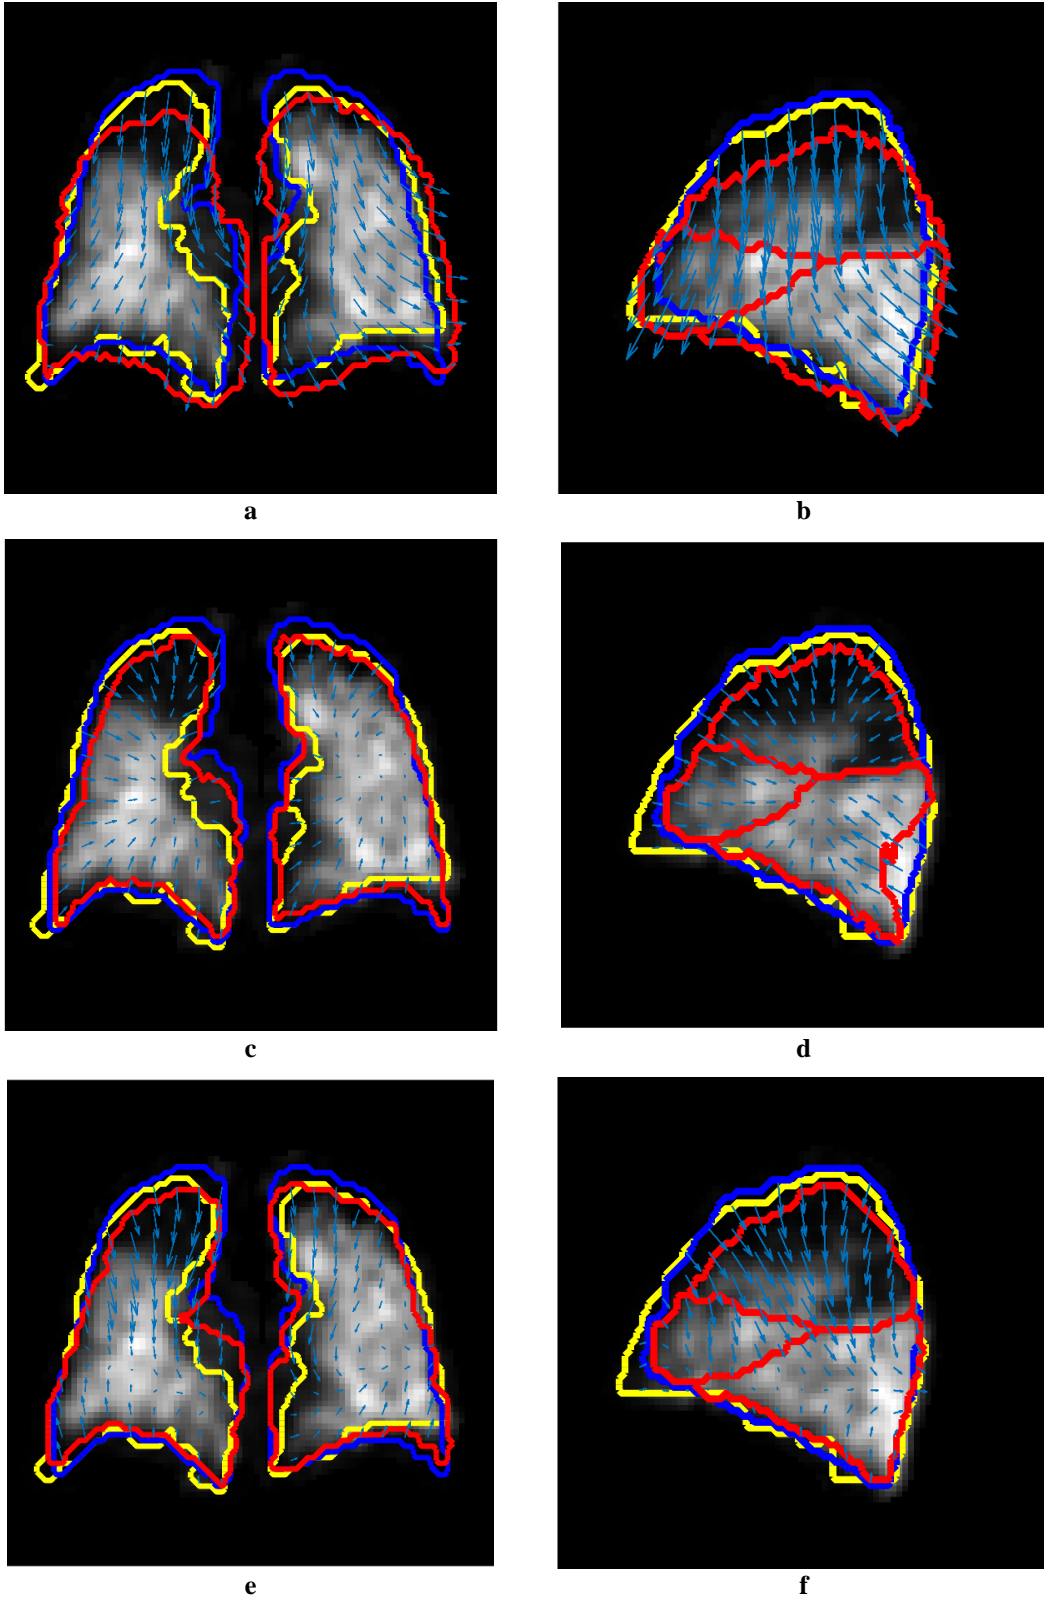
Single-channel registration results for the NiftyReg (Row 1), Ref (Row 2) and proposed (Row 3) methods with accuracies 0.805, 0.818 and 0.835 against the initial 0.810. Blue contours indicate the ground-truth boundaries of the lung region in the SPECT scan (target). Blue arrows indicate the deformable field in non-rigid registration. (a,c,e) Coronal view: yellow and red contours represent the boundaries of the lung region in an MSCT scan (source) before and after deformation respectively. (b,d,f) Sagittal view: yellow and red contours represent the boundaries of the lung region before deformation and the lung lobes after deformation respectively.
